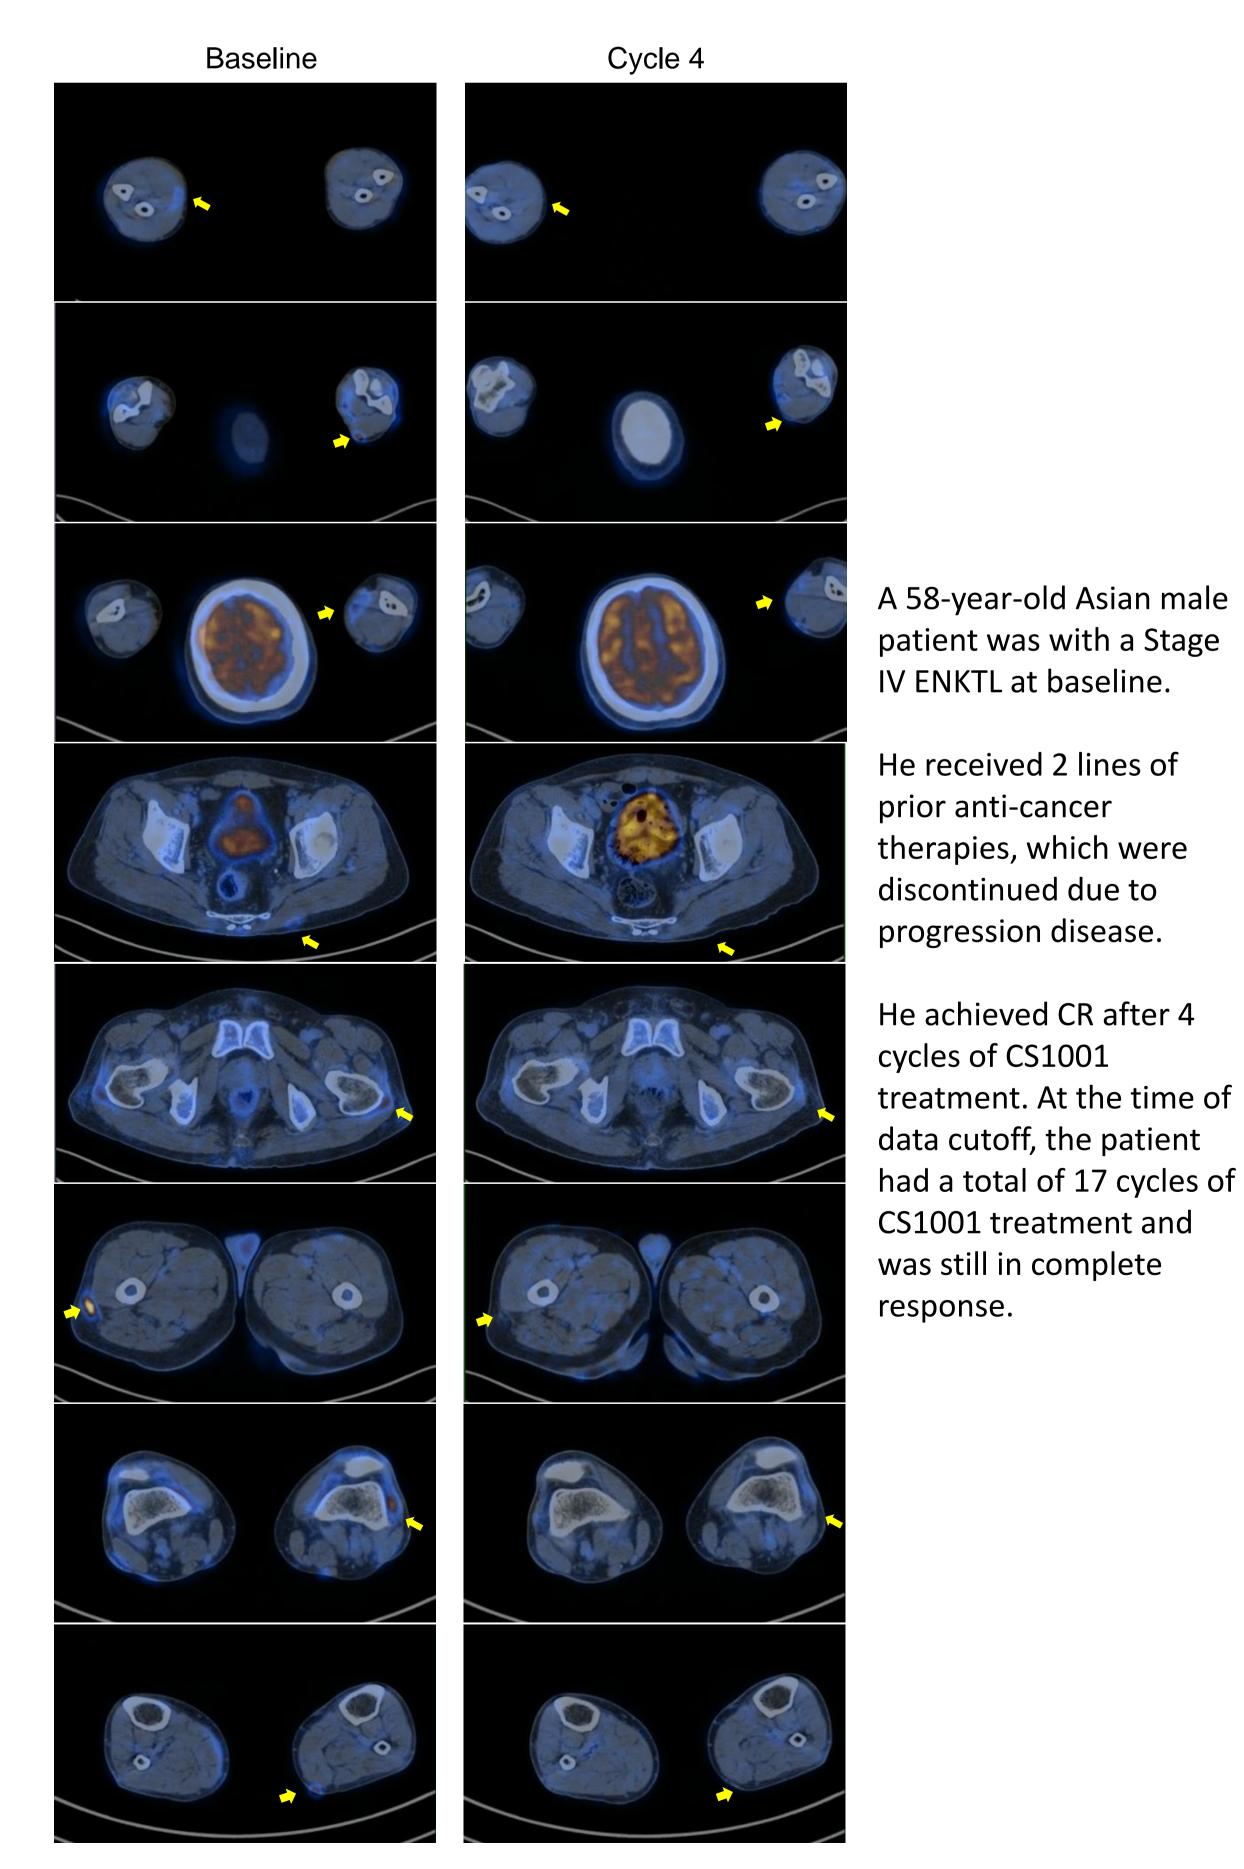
PET/CT Image for a Patient with ENKTL
